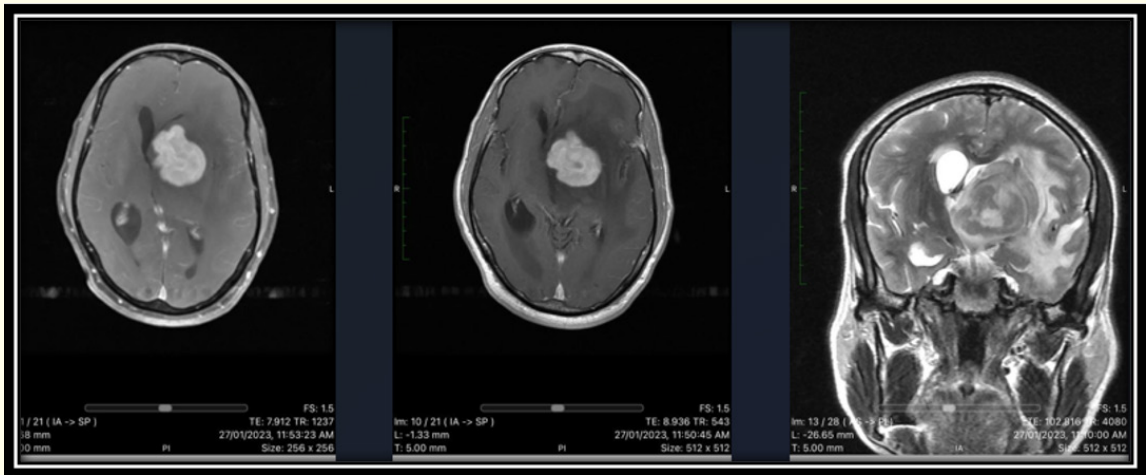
MRI Images representing left basal ganglia mass with evidence of edema and hydrocephalus.
